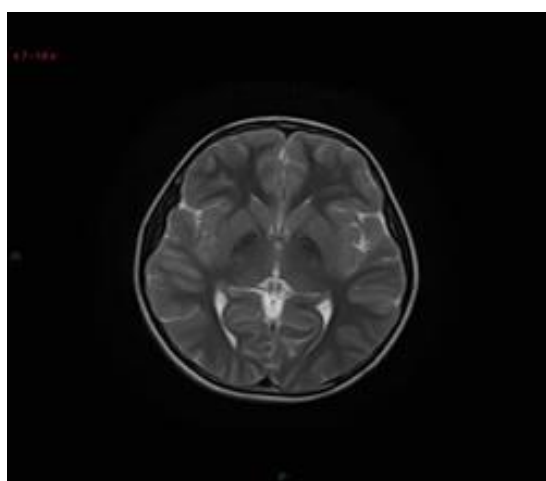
Axial T2 MRI brain.
